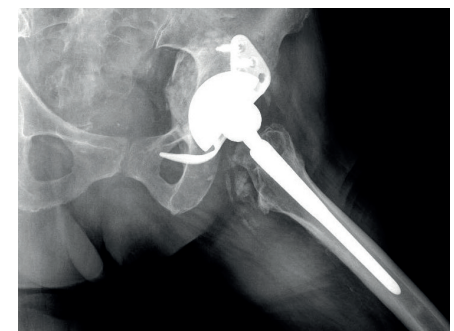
Control X-ray one month after the revision procedure; the large amount of grafted material is observed clearly.
